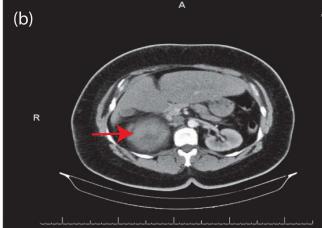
Abdominal CT. (A) Coronal view; (B) axial view.
